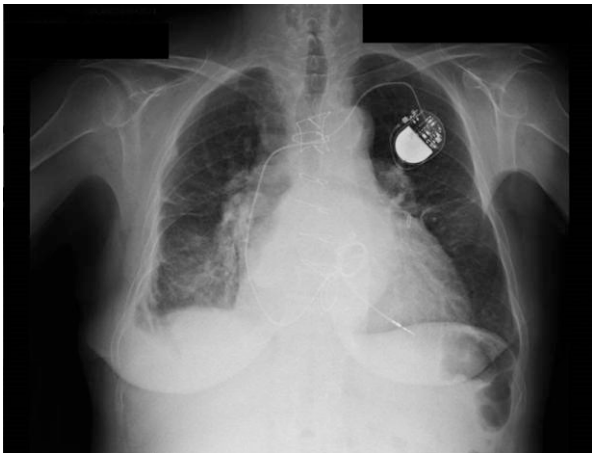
Posteroanterior chest X-ray showing the three prostheses and the CardioMEMS device.
